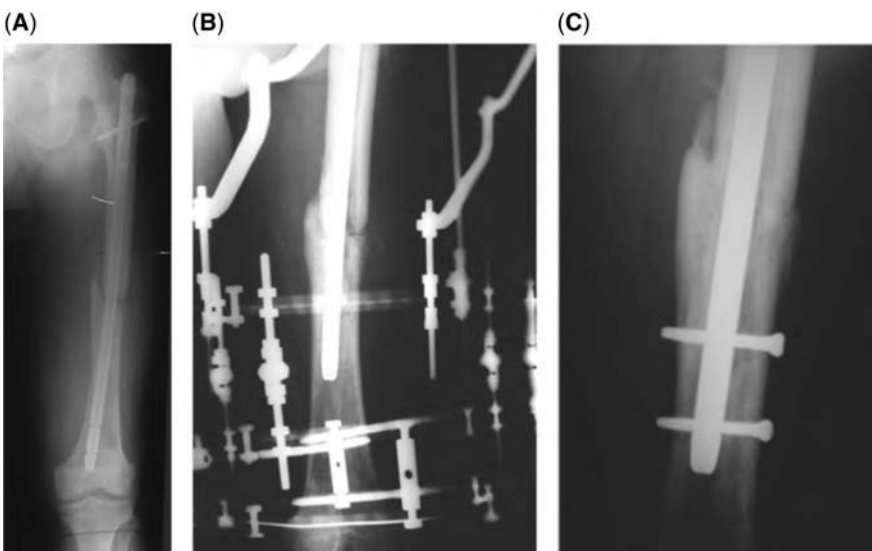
(A) Presenting anteroposterior (AP) radiograph of a 67-year-old man referred in for a nonunion 30 months following an open femoral shaft fracture and seven previous surgeries, including two previous exchange nailings and bone grafting. (B) AP radiograph on postoperative day 75 showing slow compression over a nail using external fixation (SCONE). (C) Follow-up AP radiograph four months following SCONE shows solid bony union.
